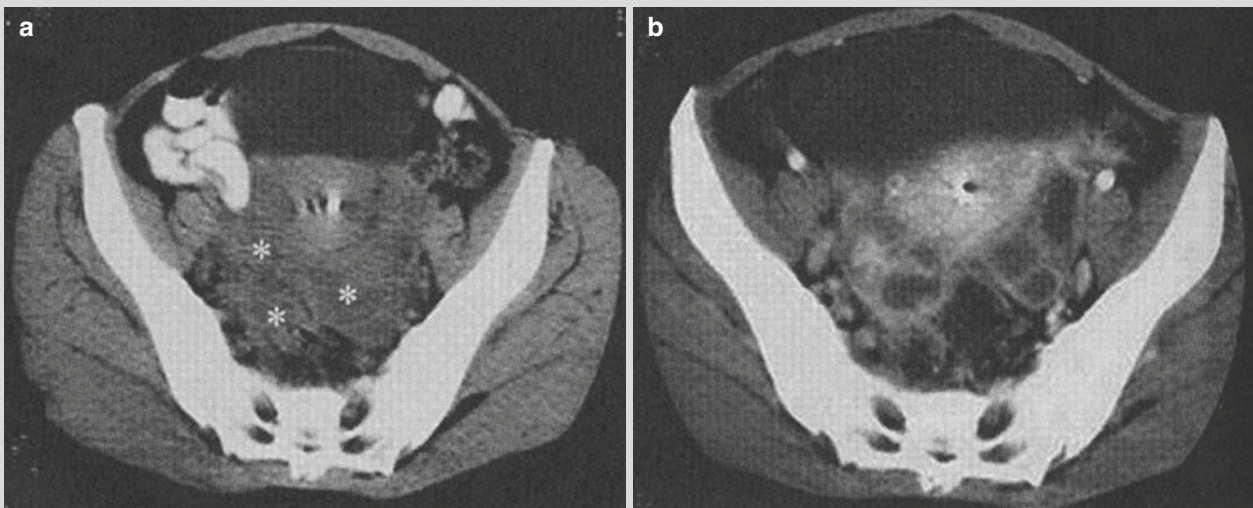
Pelvic inflammation. (a) CT plain scan demonstrates ill-defined masses with inhomogeneous density around the uterus (indicated by *asterisk*) in which contains obscured low density.
